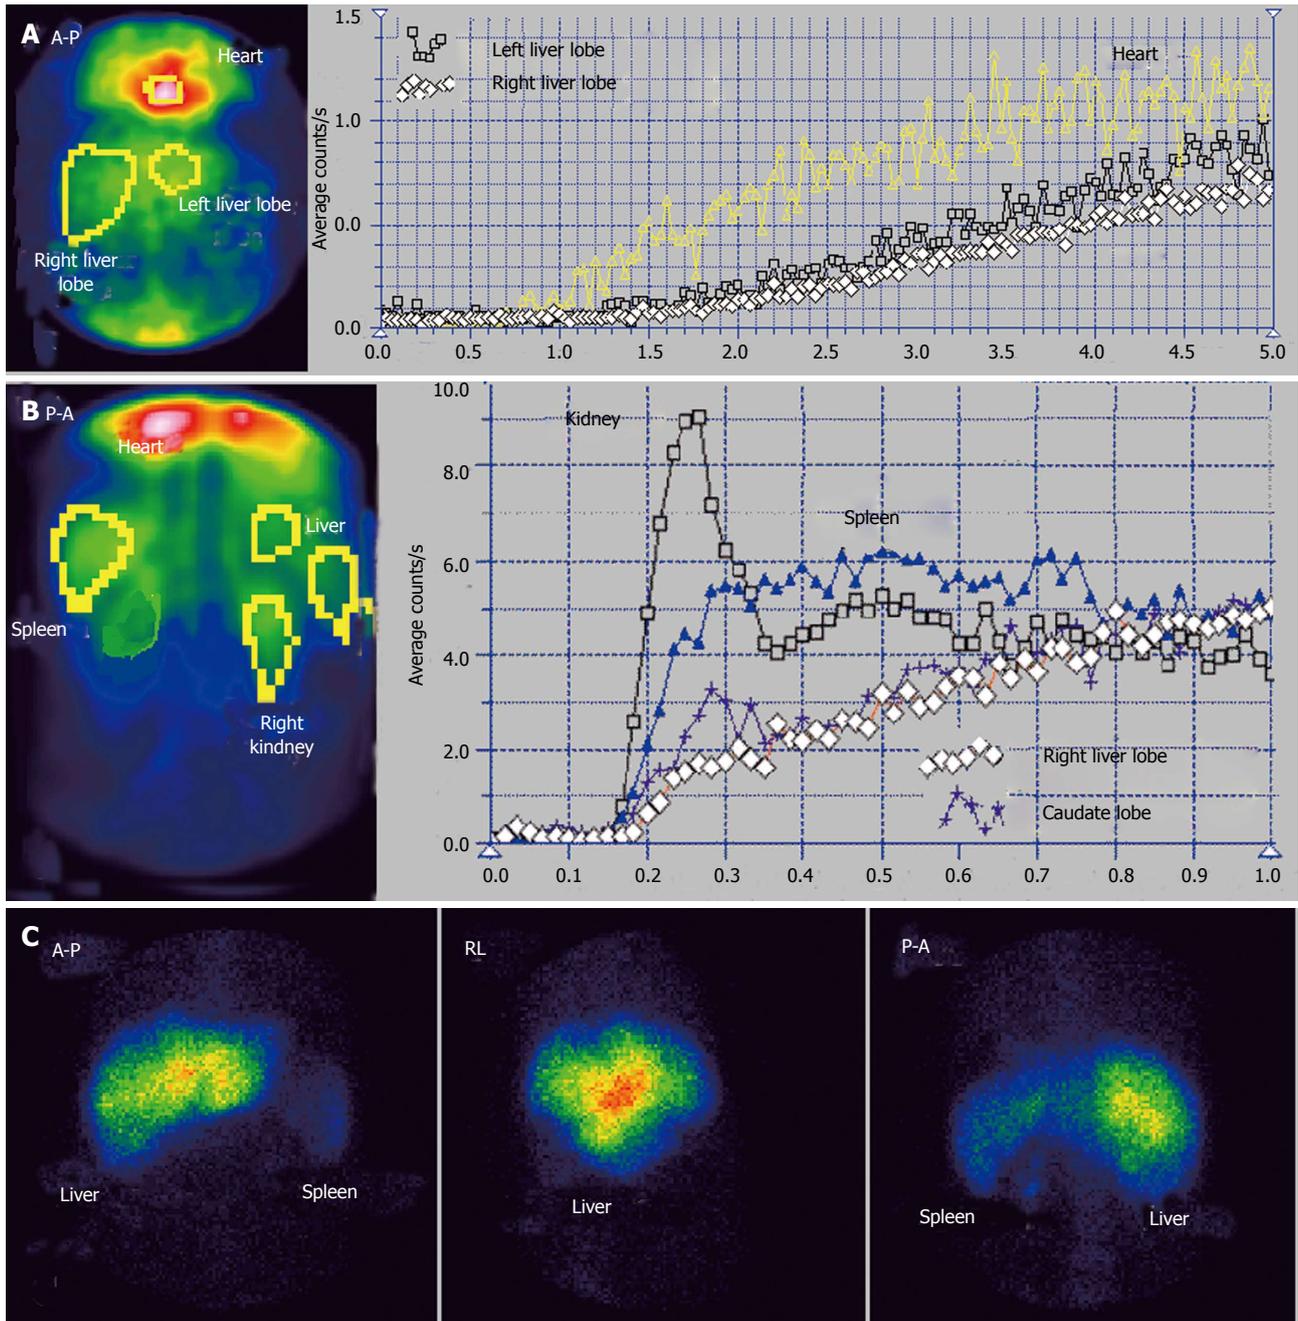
Budd-Chiari syndrome with old obstruction of the middle and right hepatic veins also followed by old obstruction of the left hepatic vein. A: Perirectal portal scintigraphy; B: Liver angioscintigraphy; C: Liver scan.
